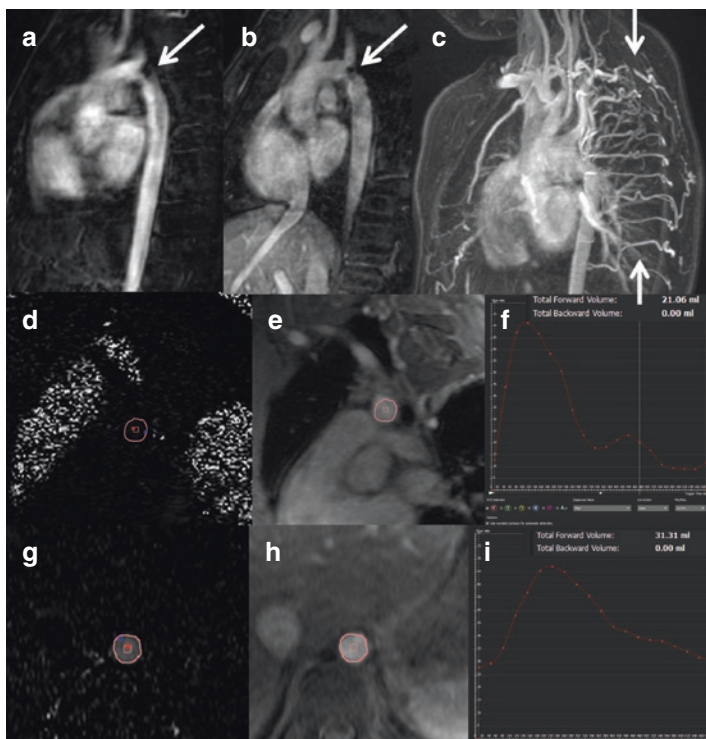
Aortic coarctation: quantitative assessment by MRI. Arterial (a) and equilibrium (b) enhancement phase images in the ‘Candy Cane’ view show an abrupt narrowing of the aorta just distal to the take-off of left subclavian artery (better depicted on the cine images; gif). Thick maximum intensity projection (MIP) image (c) is showing multiple dilated inter-costal collaterals. The contribution to the distal aortic flow via these collaterals can be quantified by phase contrast imaging (d–i). Measurements just proximal to the narrowing (d–f) show a forward flow of 21 cc, while distal descending thoracic aorta (g–i) shows a forward flow of 31 cc; suggesting approximately 32% $[(31-21)/31]$ contribution from the collateral flow
